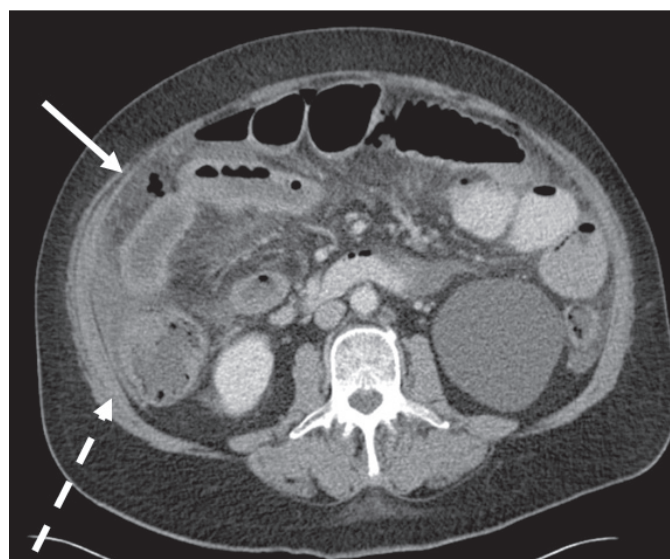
Computed tomography scan demonstrating free air (solid arrow) and cecal pneumatosis with surrounding stranding (broken arrow).
